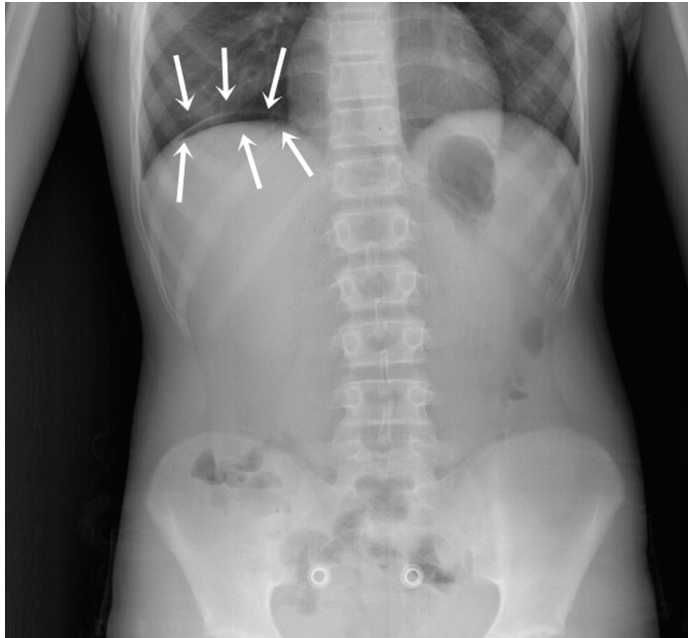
The appearance of a 1-day plain abdominal x-ray of a 12-year-old female patient who was operated on for appendicitis. Free air on the right liver (Arrows).
